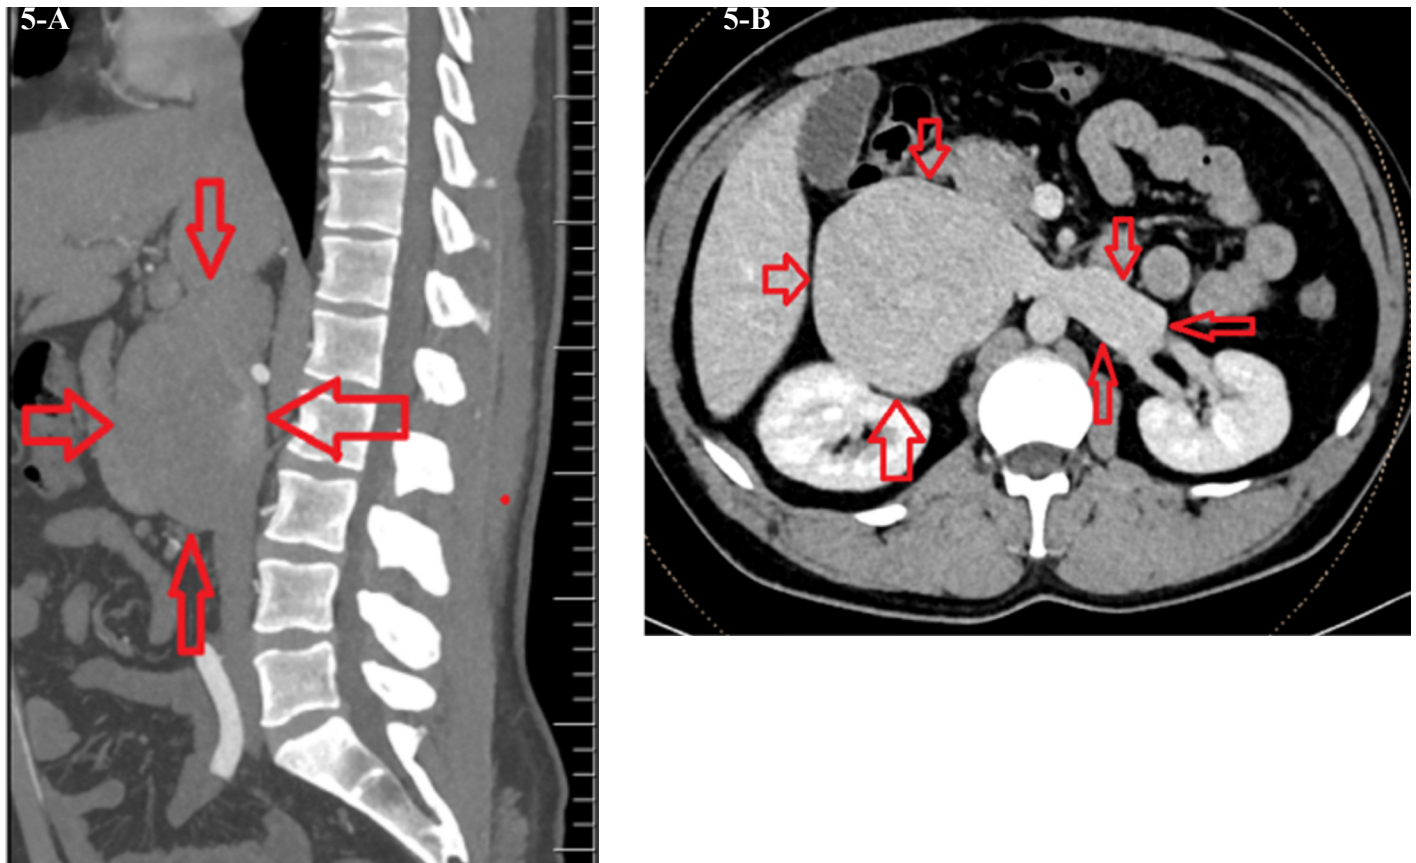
A-B. November 2020 CTA
